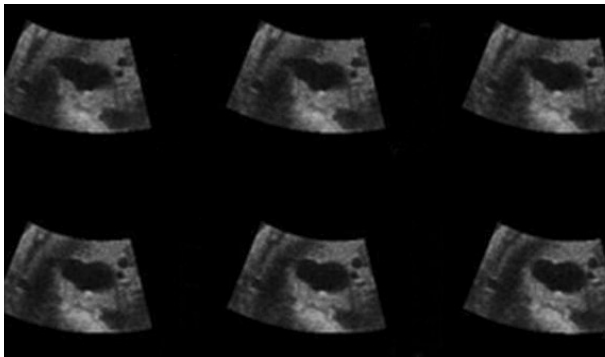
Transverse view of 3-D multislice ultrasonography shows serial dimensions of an anechoic cyst.
